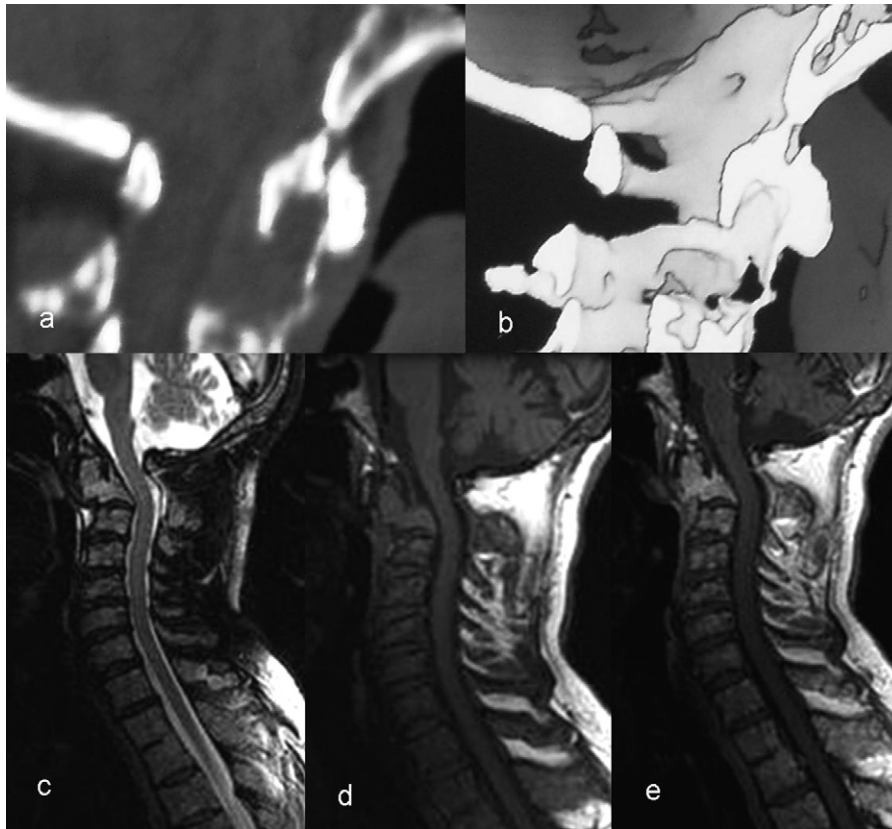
(a and b) 3D Sagittal reformatted CT images showing destruction and cortical disruption of the base of the odontoid from the body of C-2 with anterior subluxation of C1. Sagittal T2 WI (c), T1 WI (d) and post contrast (e) MRI of the cervical spine showing myelomatous deposits in the body of C-2. The deposit at the base of odontoid has an enhancing soft tissue component and is associated with pathological fracture and anterior subluxation of C1.
